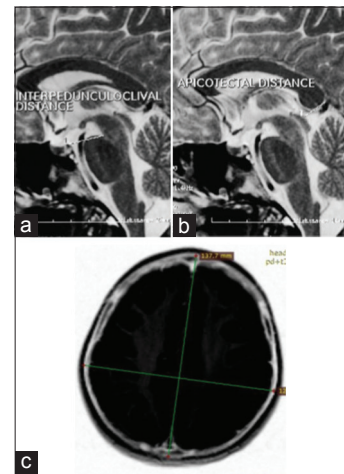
Measurements in MRI
